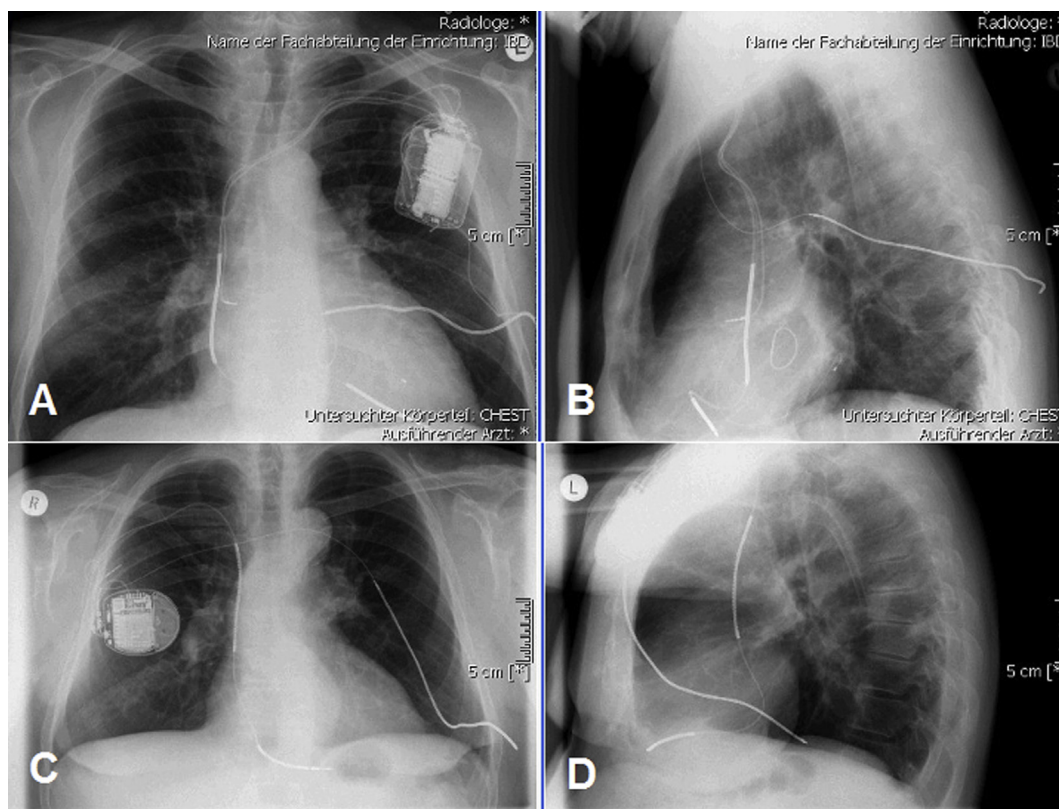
Chest x-ray image (posterior-anterior and lateral projection) of an ICD device plus subcutaneous array electrode (Panel A and B: left sided ICD implantation; Panel C and D: right sided ICD implantation).
